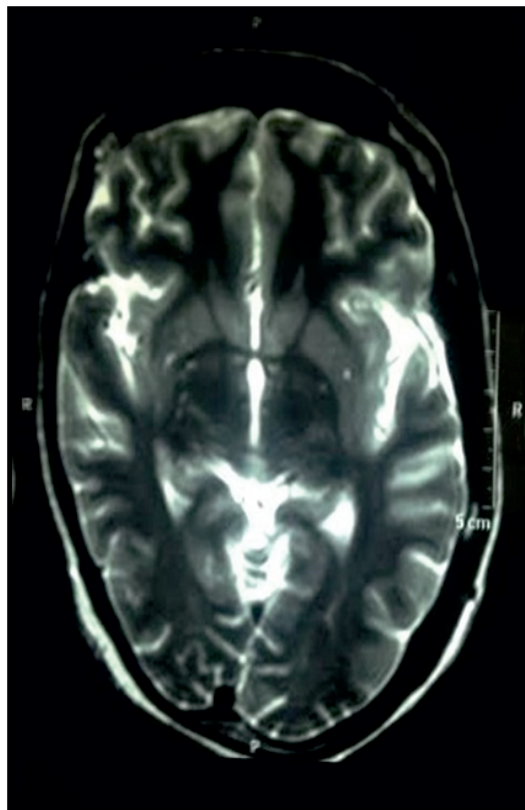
MRI Brain:-T2 & FLAIR images showing a hyper intensity signal in bilateral caudate nucleus, putamen and pulvinar of thalamus
